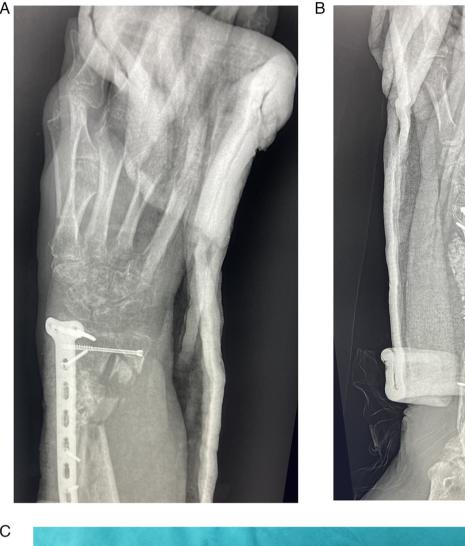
(A) Bone grafting and plate fixation were performed at the radial defect. The distal ulna and distal radius were fixed with a screw and the modified Sauve-Kapandji operation was performed to restore the stability of the wrist. (B) The sufficient bone graft in the forearm radial defect was observed by digital X-ray lateral film. (C) The successful outcome of forearm limb salvage.
